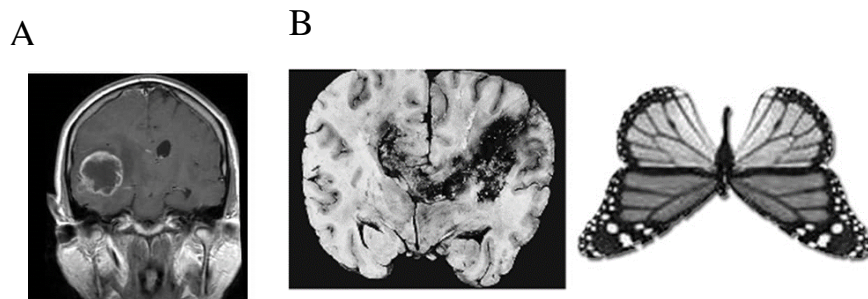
GBM MRI images. A) ring-shaped GBM with a hypodense center due to necrosis and a surrounding hypodense peritumoral area due to oedema. B) Butterfly shaped GBM due to tumour infiltration across the midline of the corpus callosum.
